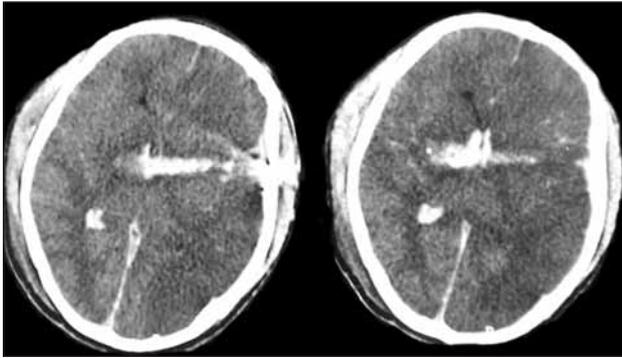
Two slices CT scan of a patient with craniocerebral penetrating injury by bullet. The trajectory filled with blood crossed the midline and lateral ventricles.
